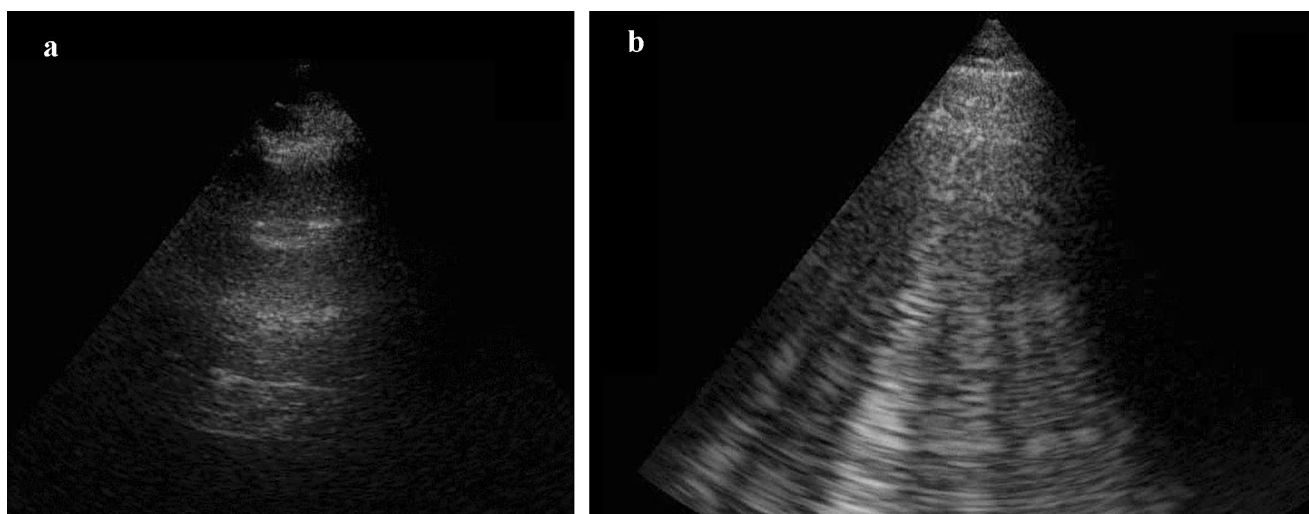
Images from the lung ultrasound from two different sites from patients from our study, showing 0 (a) and 10 B-lines (b)
